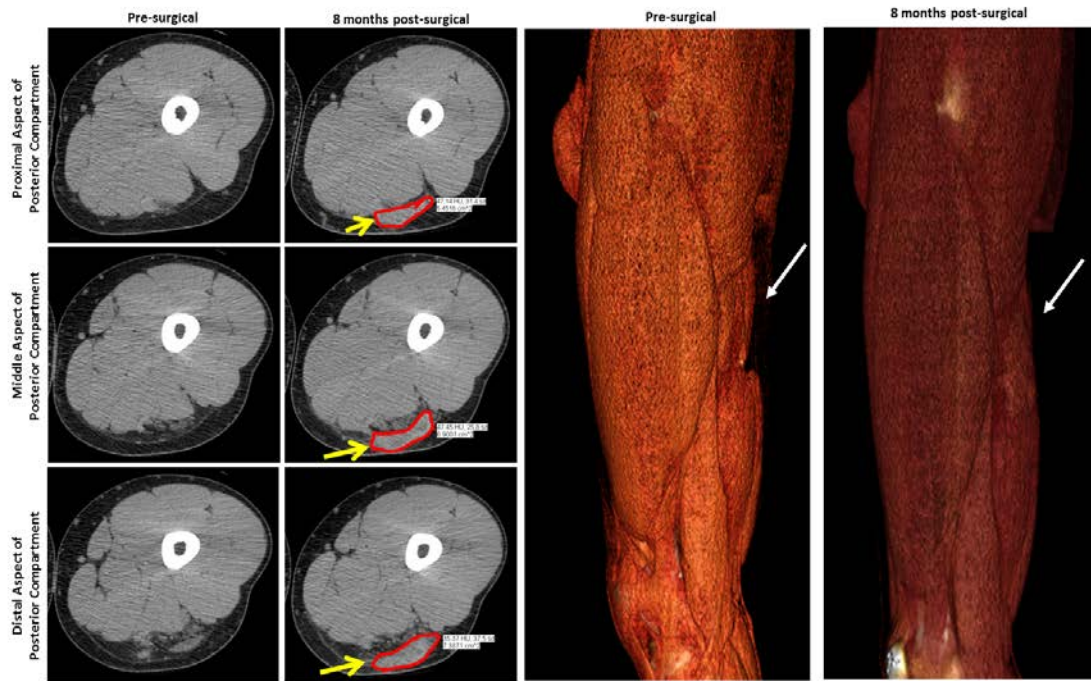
CT images of human hamstring VML after ECM bioscaffold implantation. ECM bioscaffold implantation resulted in bulk muscle formation in the human hamstring after 8 months as shown by CT imaging (yellow arrow, bulk muscle tissue formation outlined in red).
